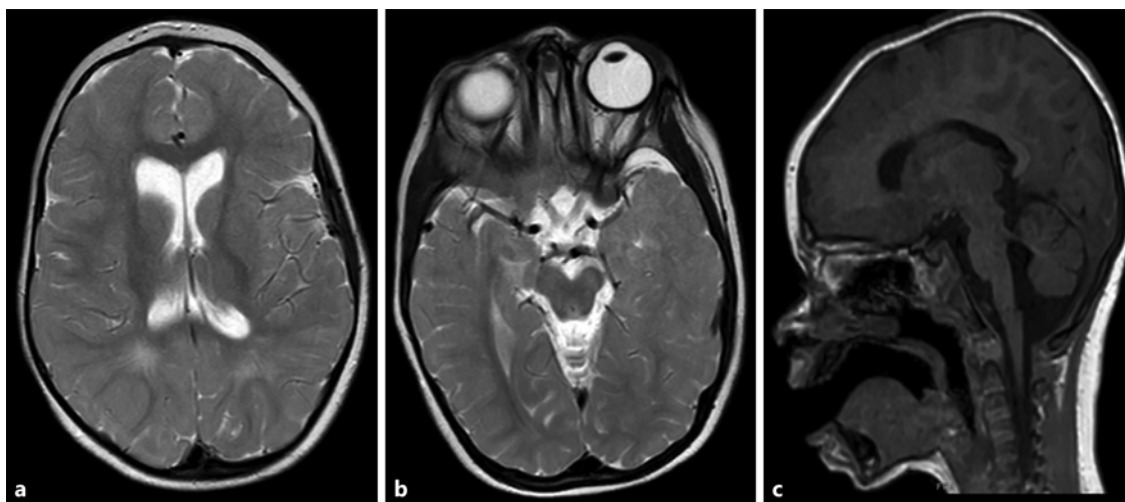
Axial (a, b) and sagittal (c) MRI view of our patient. The brain MRI shows cerebellar hypoplasia of cortical gyri, inferior cerebellar vermis hypoplasia with an enlarged fourth ventricle communicating with the cisterna magna (suggesting a Dandy-Walker variant), focal reduction in size of the corpus callosum (part of the isthmus and splenium), lateral ventricle enlargements with square-shaped anterior horns, and subarachnoidal space enlargements in the temporo polar area.
